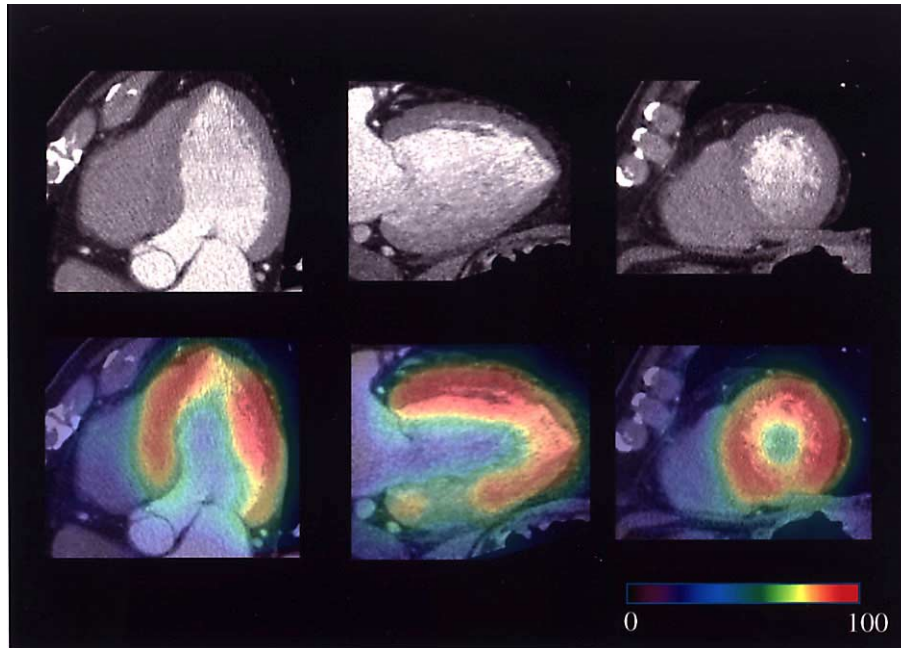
Horizontal long, vertical long and short axis slices of CTCA images (*top row*). Registered SPECT images are overlaid on the CTCA images (*bottom row*).
